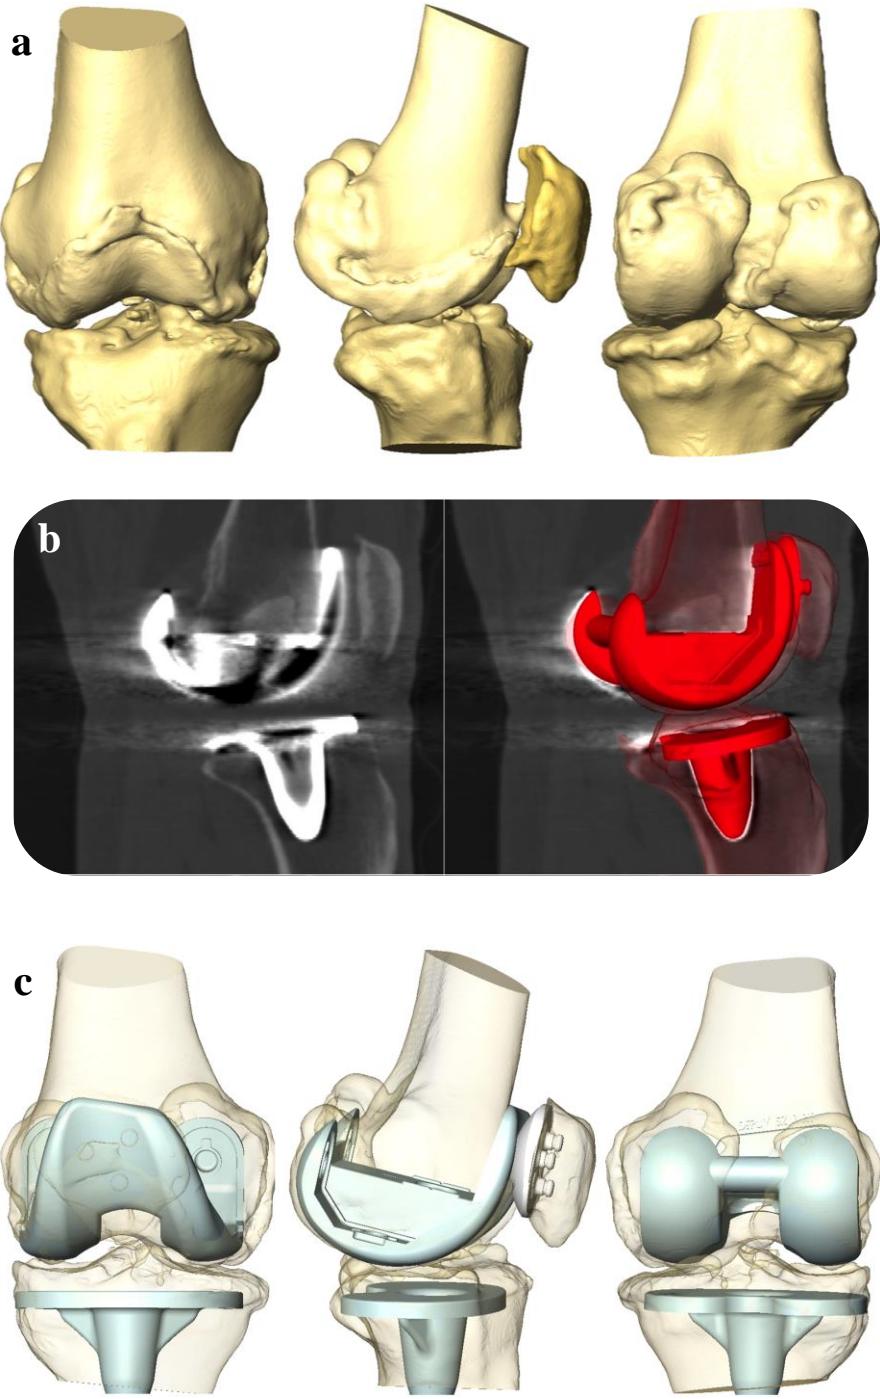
Image segmentation and prosthesis model fitting(a) Segmented preoperative bones; (b) accurate 3D-3D matching of the manufacturer-provided implant models to the CT volume despite substantial metal artifact; (c) implants overlayed on preoperative bones (tibial insert not shown due to radiotransparency of the polyethylene).
